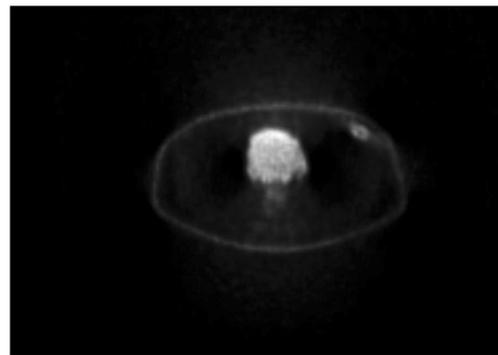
Positron emission tomography scan showing an area of high standardized uptake values (SUV) consistent with a soft-tissue metastasis
